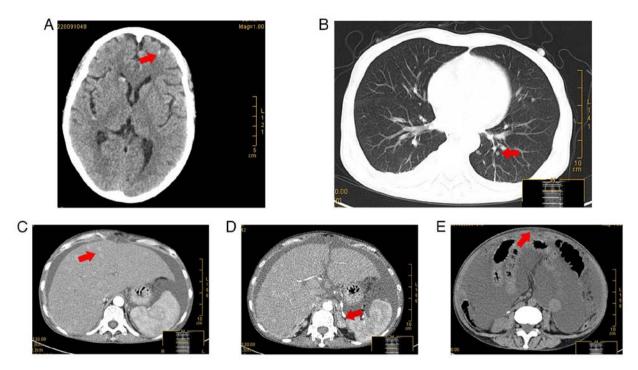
Computed tomography scans of the patient. Metastatic lesions in the (A) brain, (B) lungs, (C) liver, (D) left adrenal gland and (E) peritoneum were detected.
